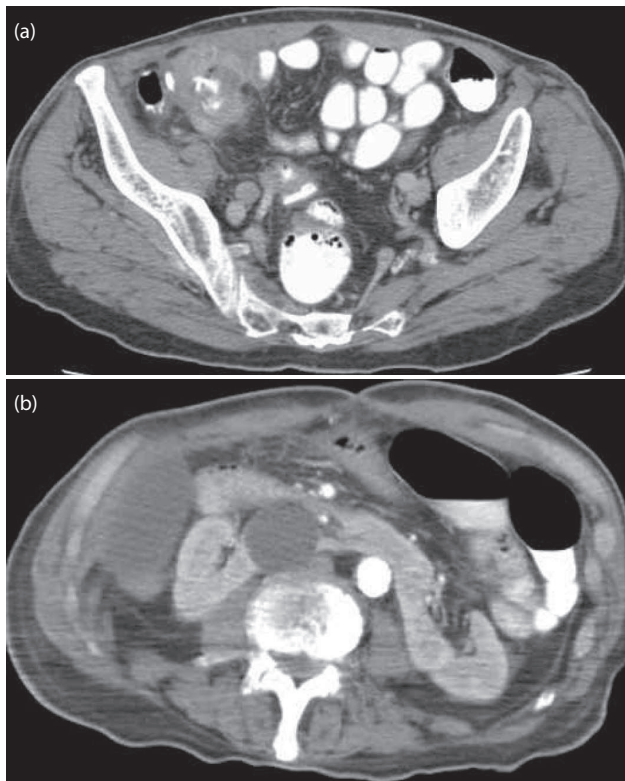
Computed tomography (CT) showed (a) thickening of cecum wall with luminal narrowing and (b) horseshoe kidney with a giant simple cyst at the isthmus of the renal fusion.
